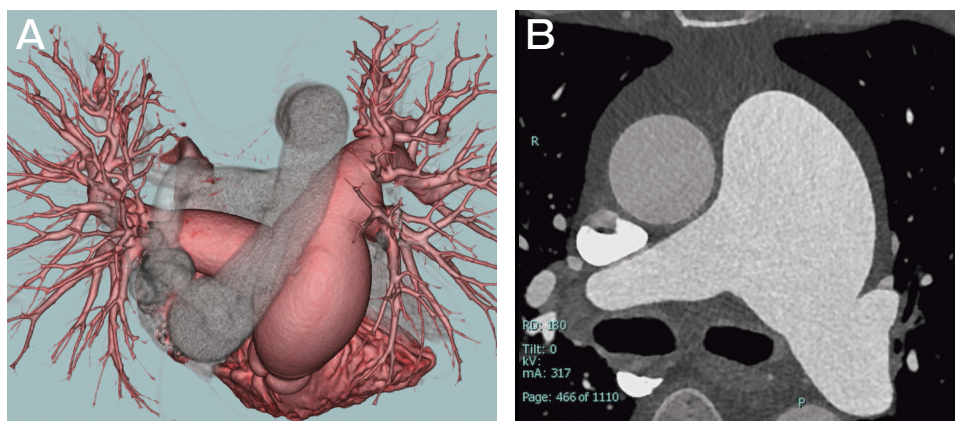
A, Three-dimensional computed tomography (CT) showing pulmonary artery aneurysm (PAA); B, CT showed a dilated main pulmonary artery (PA) (66.7×47.8 mm), right PA (37.1×32.9 mm), and left PA (36.7×34.0 mm).
